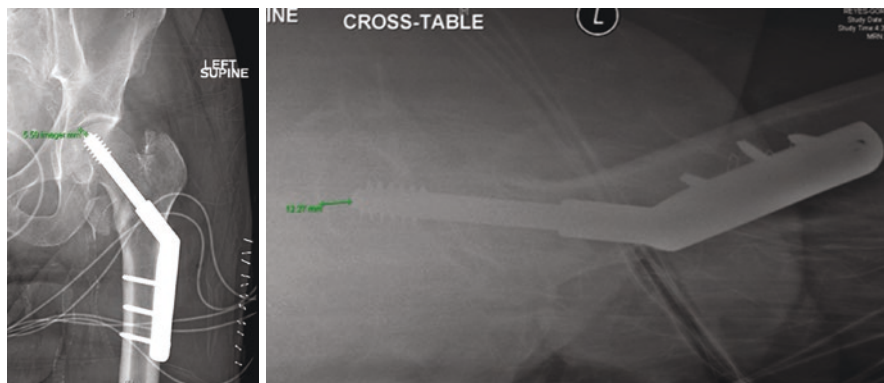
Postoperative X-rays following sliding hip screw
